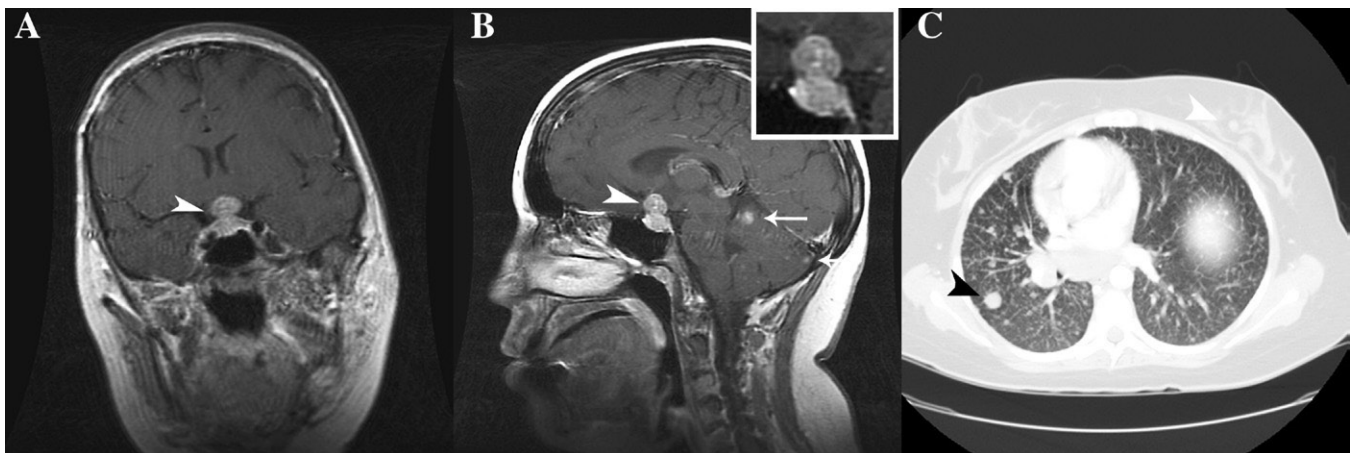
Imaging studies. Panels (A) and (B) are T1-weighted postcontrast magnetic resonance imaging sequences showing a bilobed enhancing mass filling the sella turcica and suprasellar region (arrowheads and inset) and presumptive cerebellar metastases (arrows). Panel (C) is a computed tomographic scan image of probable lung metastasis (arrow).
